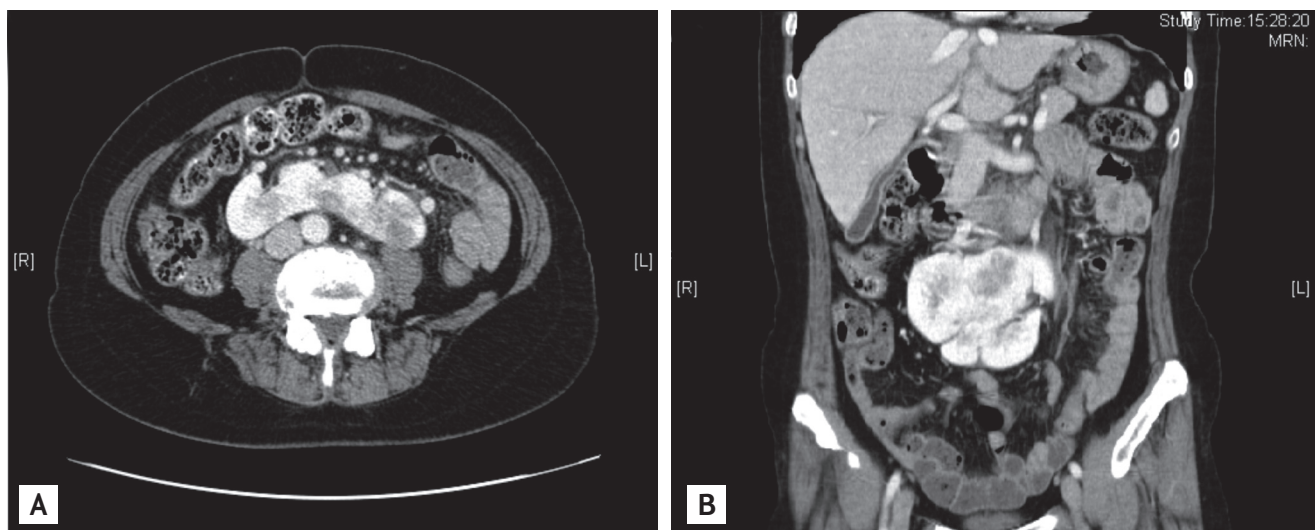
Enhanced abdominal computed tomography scans of the patient. (A) An axial scan shows fused kidneys with multiple low density lesions anterior to aorta and inferior vena cava. (B) A coronal scan shows fused kidneys located in the midline of the abdominal cavity.
